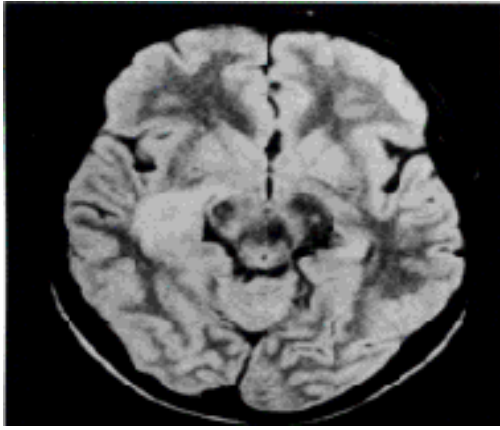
MRI axial proton density cuts showing the largest right thalamic and posterior basal ganglia hyperintense lesion involving the posterior limb of the internal capsule.
